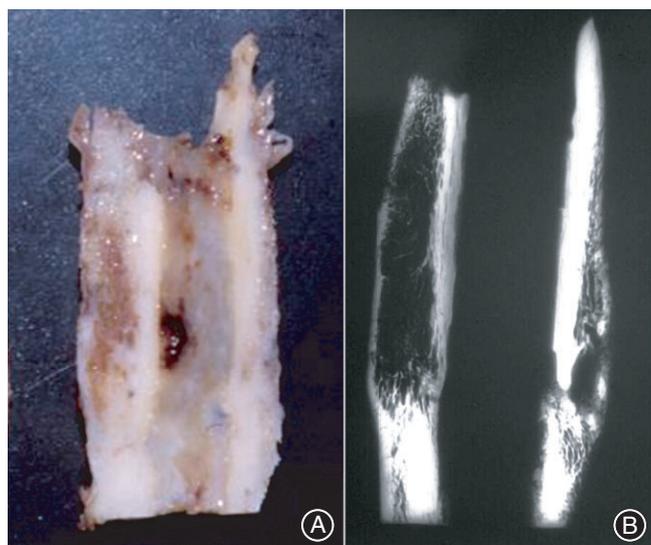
Representative case demonstrating healing of allograft fracture. The allograft of a 20-year-old woman fractured and was managed by osteosynthesis and bone autograft. Several years later the allograft had to be removed because of another fracture. Images of the healing of a fracture in an allograft: (A) Macroscopic view and (B) X-ray film of the retrieved allograft after a previous fracture. The healing of the fracture occurred through formation of periosteal callus.
